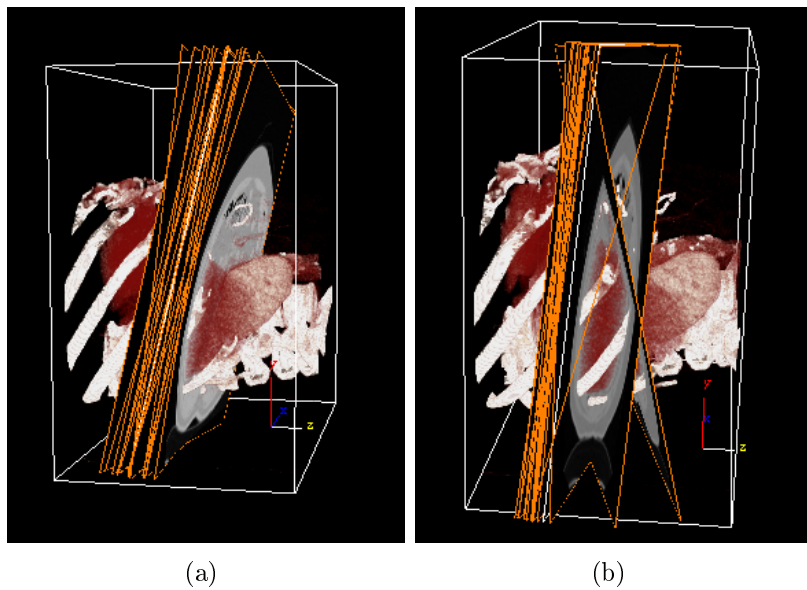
3D views of the generated CEPs. (a) AM-estimator (b) M-estimator. Notice that in the case of the M-estimator which was rated as not successful there are three planes outside the bundle. These correspond to projections where the spleen is captured, as it is present in the CT-fluoro slice. The CT-fluoro slice for this case is shown in figures 4.9(a) or 4.10(a). The slices are shown in a 2D view in figure 4.10 and correspond to the figures 4.10(j), 4.10(n) and 4.10(t). Note that they are located in the subvolume which is identified as the solution subvolume.
